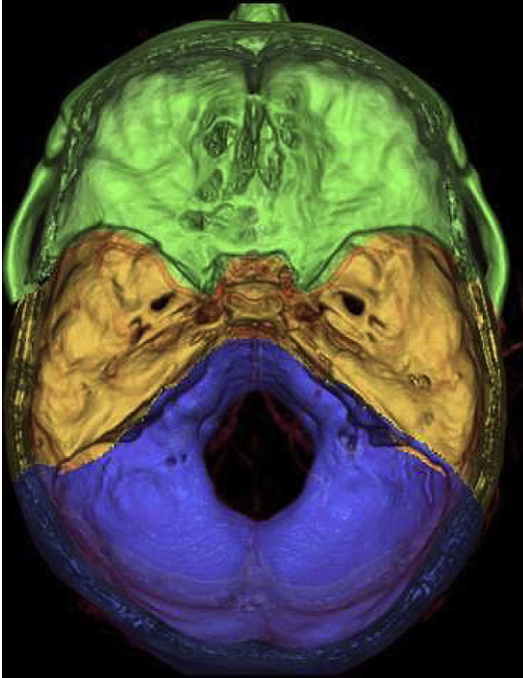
Three-dimensional CT reconstruction represents the skull base division into anterior (*green*), central (*light orange*), and posterior (*blue*) compartments.
